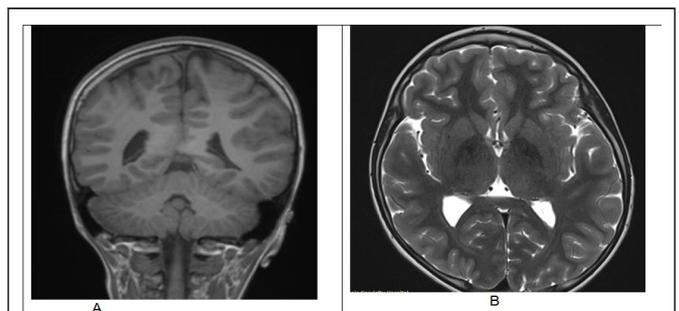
(A) Non-contrast head CT scan showing no acute hemorrhage or structural abnormalities, (B) Axial T2-weighted MRI performed on the same day showing symmetric signal intensity in the basal ganglia and thalami, without overt focal lesions or edema.
